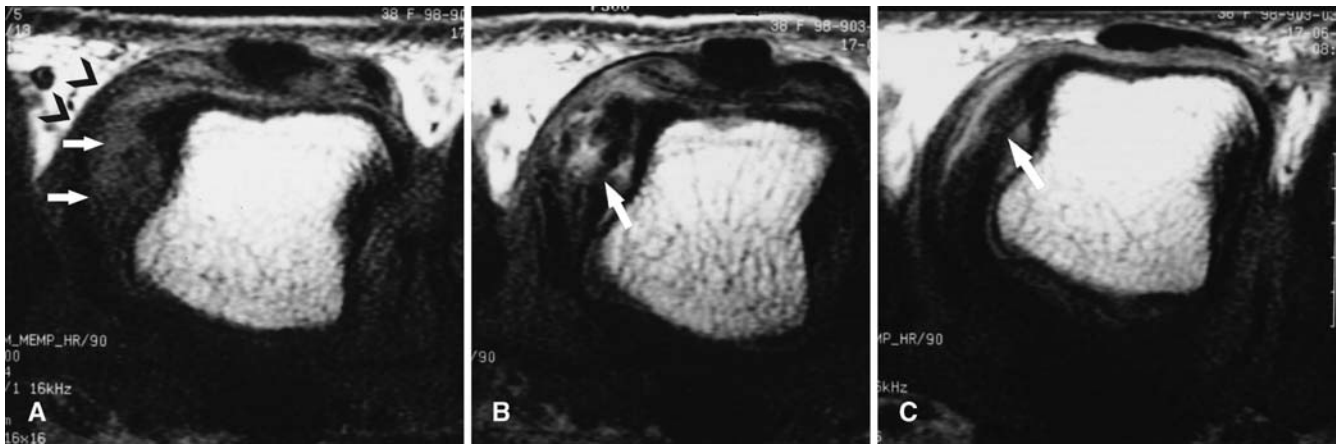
C MR images of a partial tear of the radial collateral ligament of the third left MCP joint. Axial T1-weighted (600/24) images of the extended joint A before and B after injection of gadolinium. Before injection, the radial collateral ligament is not visible and appears thickened (*arrows*) with displacement of the overlying sagittal band (*arrowheads*). After injection, the collateral
